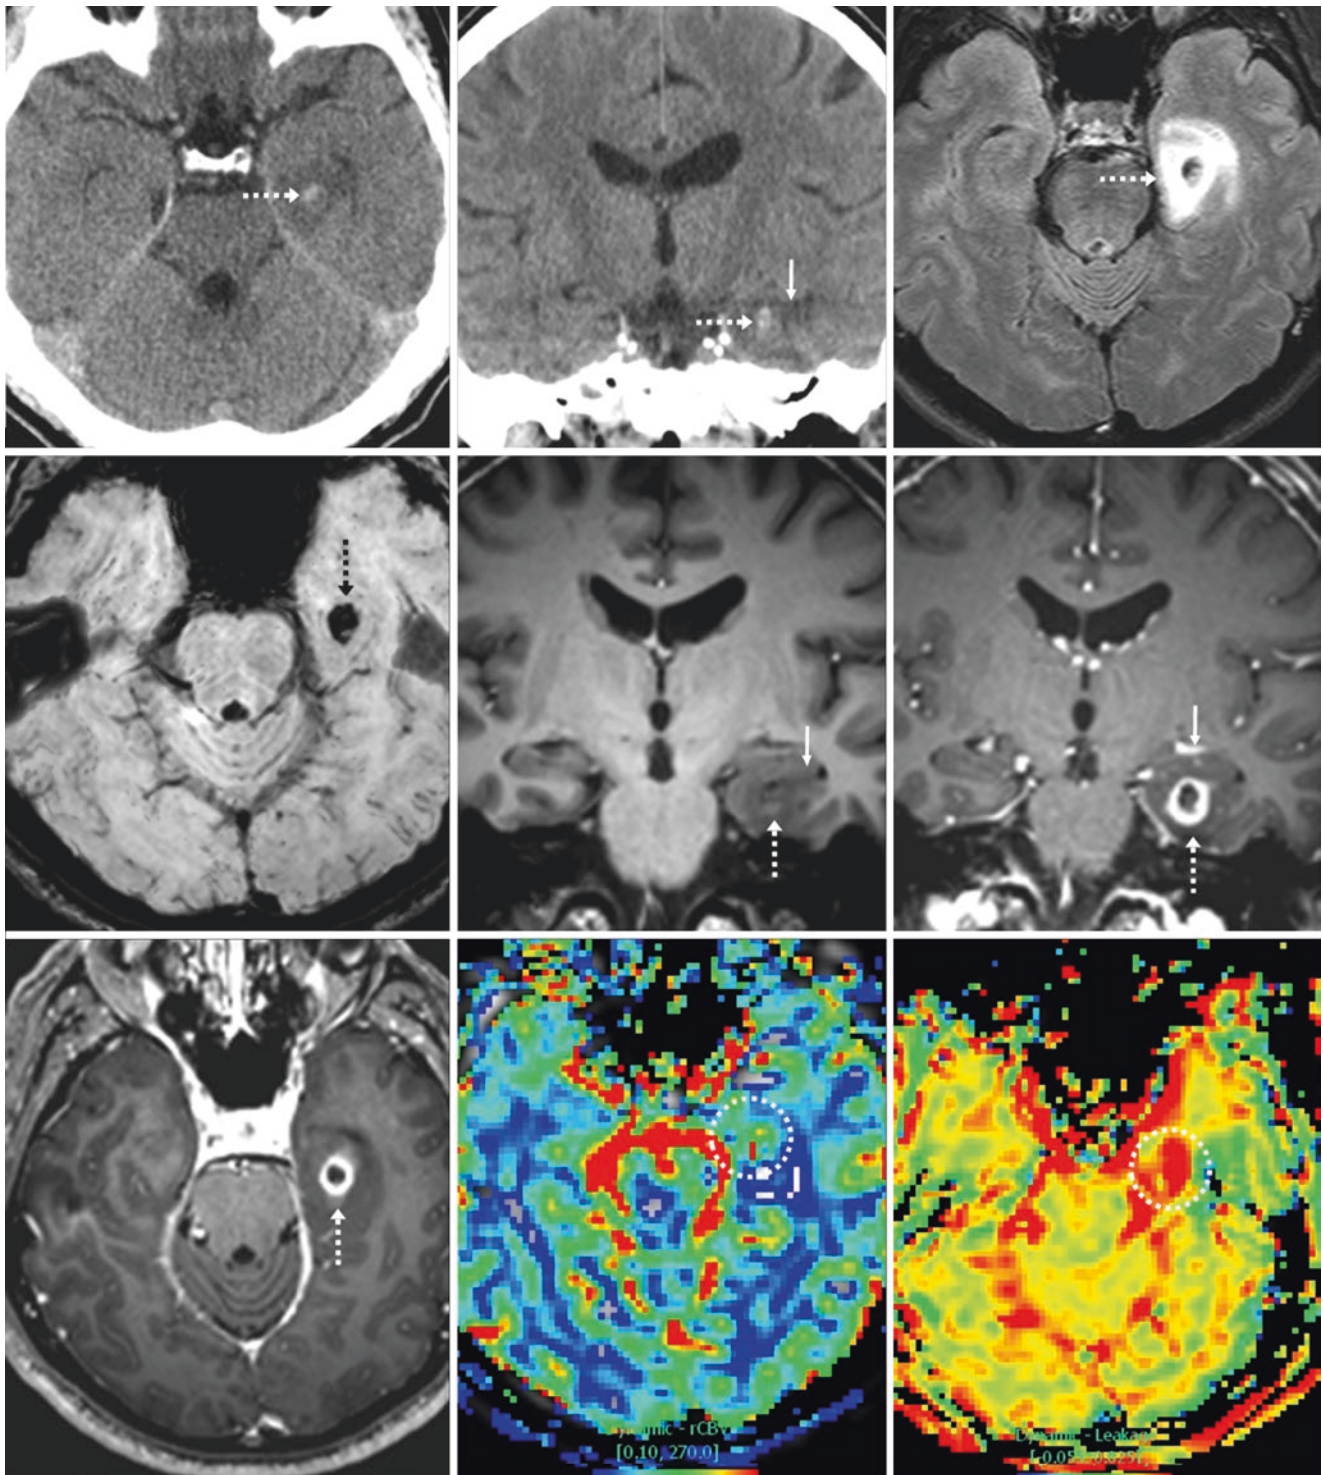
Companion case of glioblastoma. A 50-year-old patient with seizures. *Top row:* an emergent NECT showed a mildly hyperdense lesion (*dashed arrows*) on axial (*left*) and coronal (*middle*) reformats. Note mild hypodense edema surrounding the lesion, also confirmed to have surrounding edema on 3 T FLAIR (*right*). *Middle row:* SWI (*left*) depicted T2-dark hemorrhage within, with edema on noncontrast axial T1WI (*middle*) and avid enhancement surrounding
